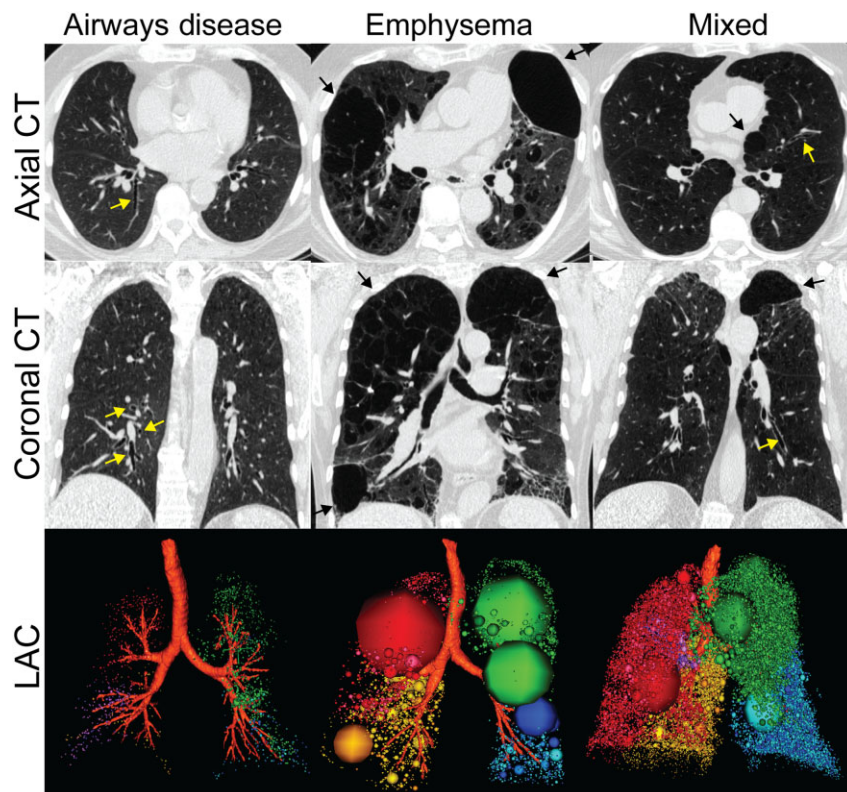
Structural thoracic X-ray computed tomography images. Axial and coronal CT and low attenuation clusters (LAC) of emphysema, represented as spheres with CT densitometry values below -950 HU registered to the three-dimensional reconstruction of the airway tree shown below. Yellow arrows indicate airways disease and black arrows indicate emphysematous regions. From left to right: airways disease dominant: $FEV_1 = 103\%_{pred}$, $DL_{CO} = 119\%_{pred}$, $RA_{950} = 1\%$; Emphysema dominant: $FEV_1 = 65\%_{pred}$, $DL_{CO} = 17\%_{pred}$, $RA_{950} = 37\%$; Mixed: $FEV_1 = 47\%_{pred}$, $DL_{CO} = 62\%_{pred}$, $RA_{950} = 15\%$.
